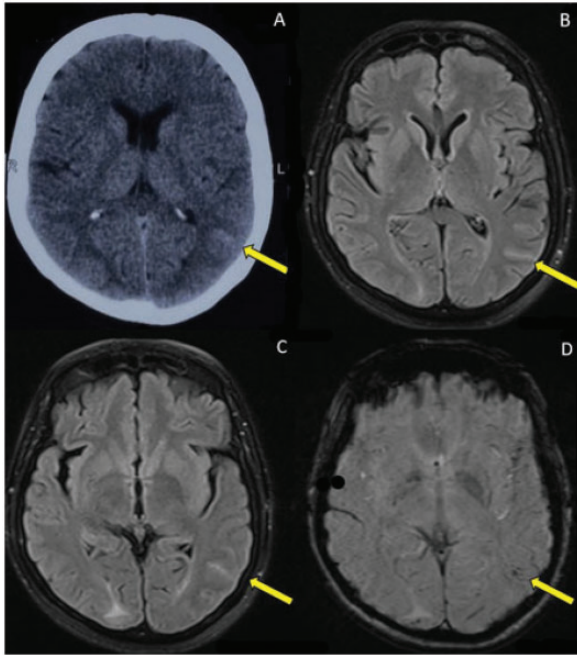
Brain imaging. A- Non-contrast CT, B, C- MRI-FLAIR sequence, D – MRI-SWI sequence
